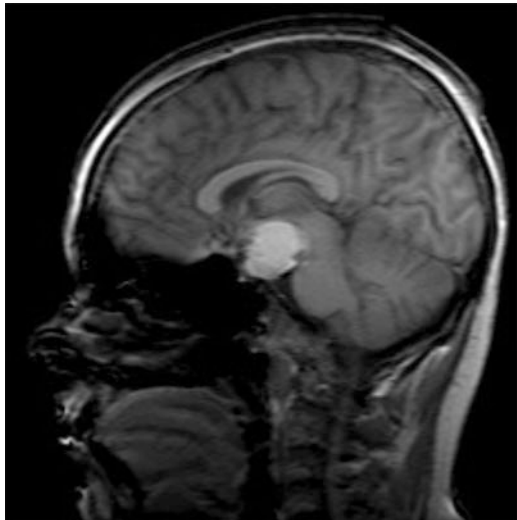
MRI scan of craniopharyngioma in patient with CPHD and diabetes insipidus (MR scan from the authors' collections)
